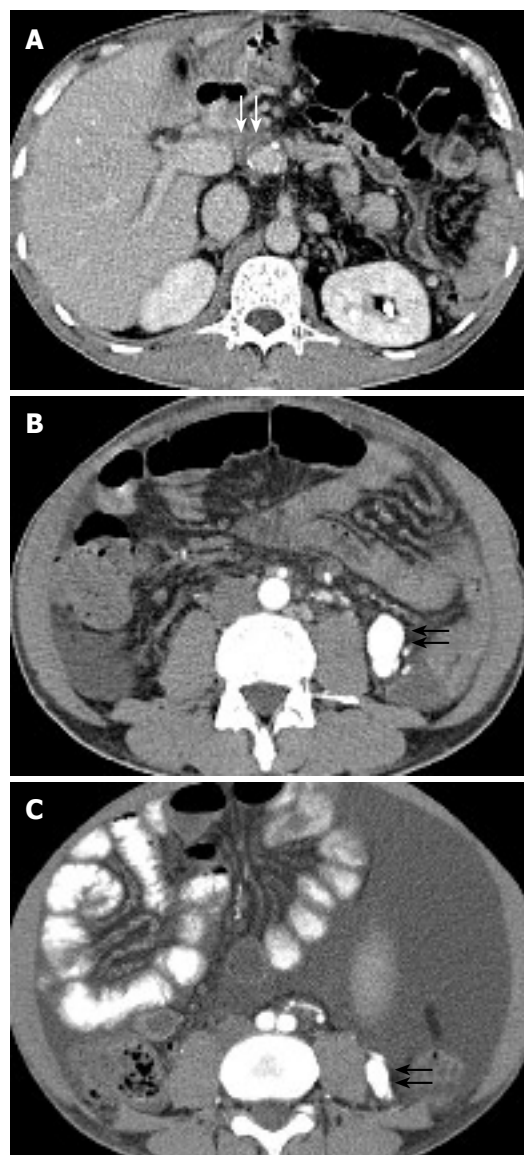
Contrast-enhanced CT of the abdomen showing portal vein stenosis (white arrows) (A), an approximately 30 mm \times 18 mm contrast-enhancing vascular mass (black arrows) (B), and an approximately 10 mm \times 8 mm enhancing vascular structure before transplantation (black arrows) (C).
